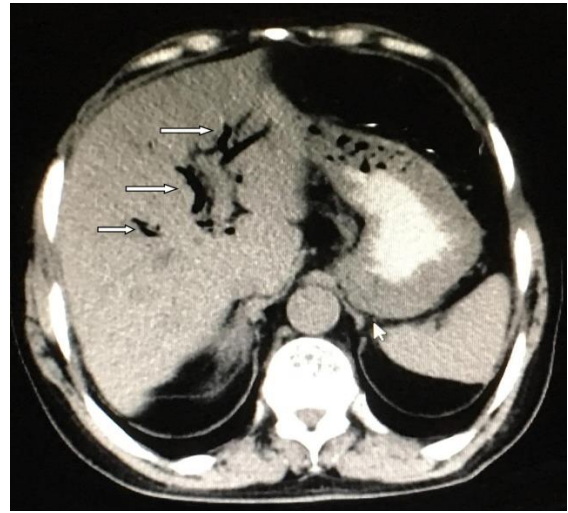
The image of the pneumobilia on the CT of the patient
